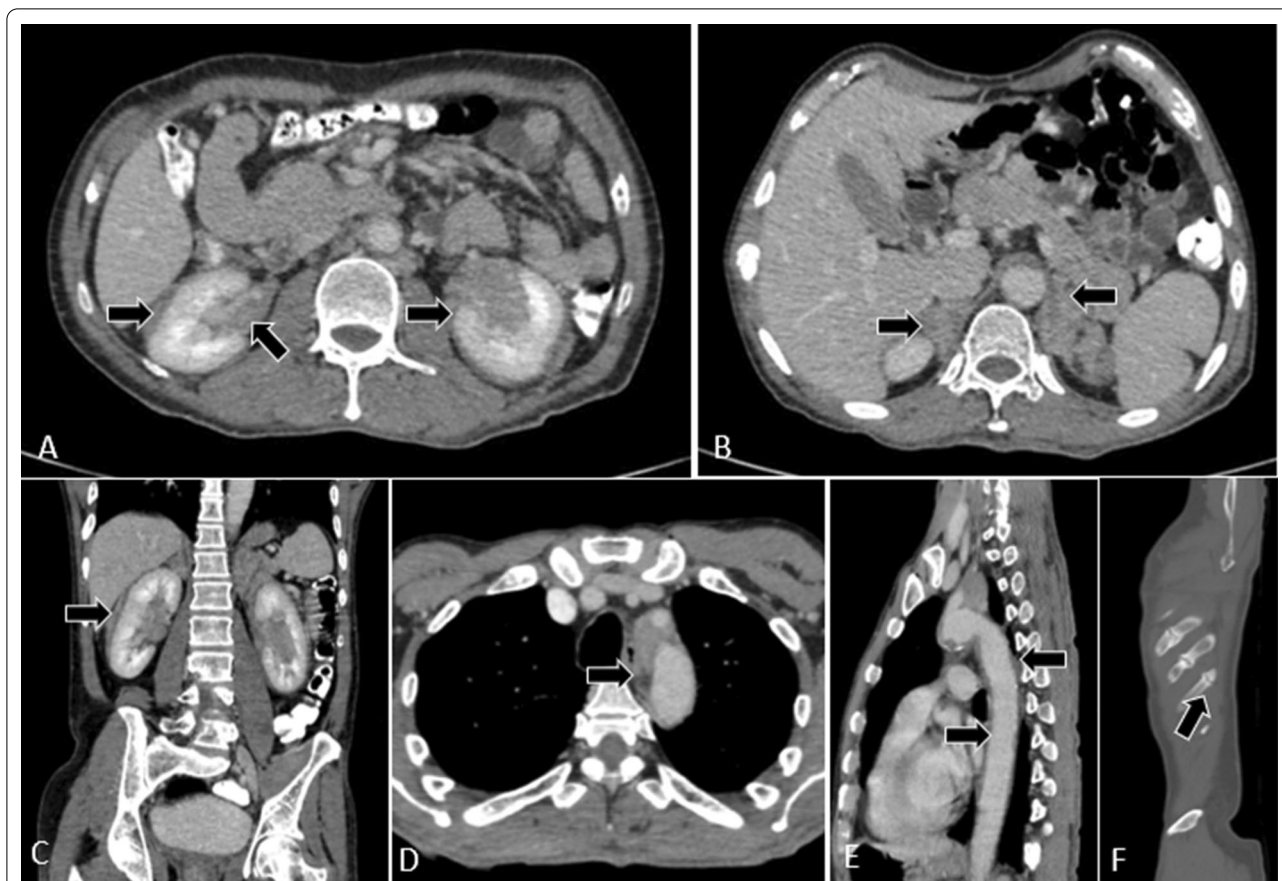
Contrast-enhanced computed tomography of a 60-year-old patient diagnosed with Erdheim–Chester disease reveals ill-defined enhancing soft tissue lesions involving bilateral perinephric spaces (hairy kidney sign) with intra-renal sinus extension encasing renal pelvis and vessels (A, C) with involvement and enlargement of both adrenal glands (B). Computed tomography study of the chest revealed soft tissue lesion encasing aorta (coated aorta sign) and origin of left subclavian artery (D, E). Old fracture of the ribs also noted (F)
